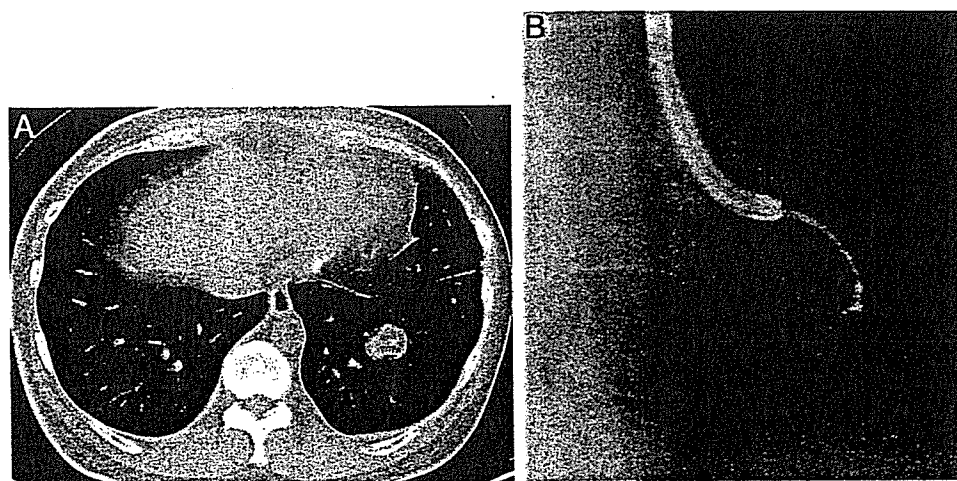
Case 2. A hamartoma. *Left, A:* a chest CT scan reveals a lesion in the left lower lobe. *Right, B:* a bronchoscopic image shows the STAF approaching a tumor through the left B10e. It forms a CS (*ie*, S-shape).
